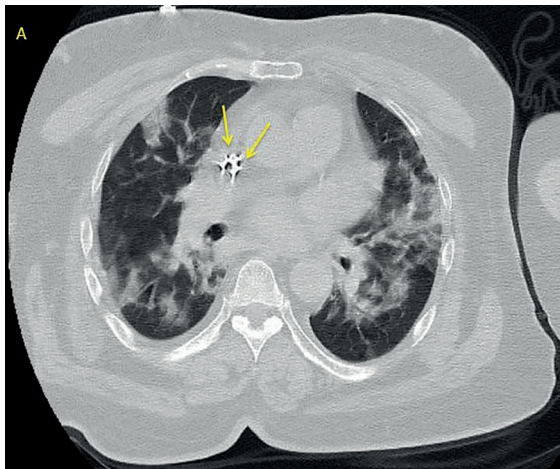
Chest computed tomography in severe COVID-19 pneumonia showing pace leads in RA and multiple lesions involving multiple lobes of bilateral lungs.
